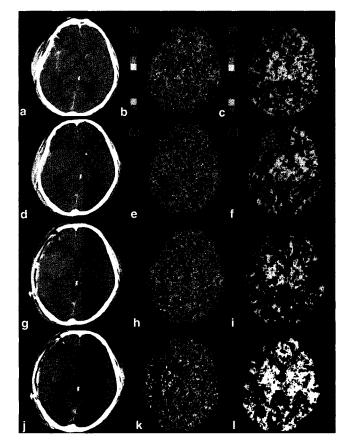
CT (a),CBF map (b) and MTT map (c) on Day 0; CT (d),CBF map (e) and MTT map (f) on Day 1; CT (g),CBF map (h) and MTT map (i) on Day 2; CT (j),CBF map (k) and MTT map (l) on Day 6. CBF values decreased on Day 1 compared to Day 0. SjO2 decreased and ICP increased on Day 1 (SjO2 was 46%, ICP was over 40 mmHg) compared to Day 0 (SjO2 was 54%, ICP was under 20 mmHg). CBF values increased on Day 2 compared to Day 1. SjO2 increased and ICP decreased on Day 2 (SjO2 was 63%, ICP was under 20 mmHg) compared to on Day 1 (SjO2 was 46%, ICP was under 20 mmHg) compared to Day 1 (SjO2 was 46%, ICP was under 20 mmHg) compared to Day 1 (SjO2 was 46%, ICP was under 20 mmHg) compared to Day 1 (SjO2 was 46%, ICP was under 40 mmHg). CBF and MTT values were good on Day 6
